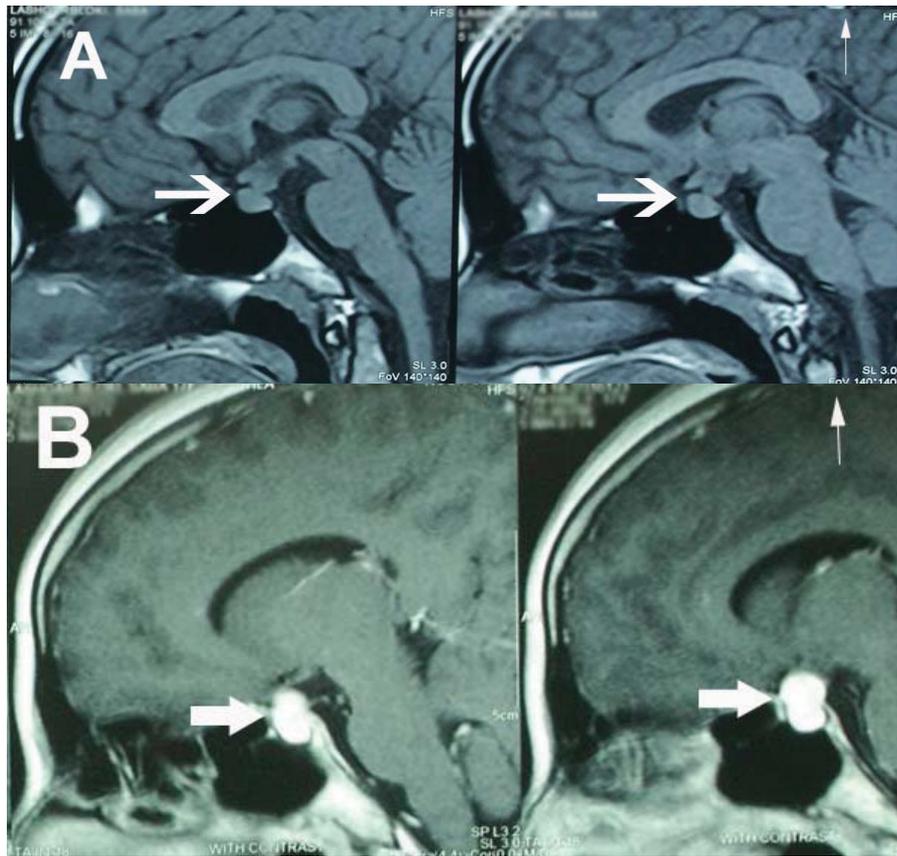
Sagittal view of brain MRI showing the thickening of the stalk. A) Without contrast; B) With contrast
